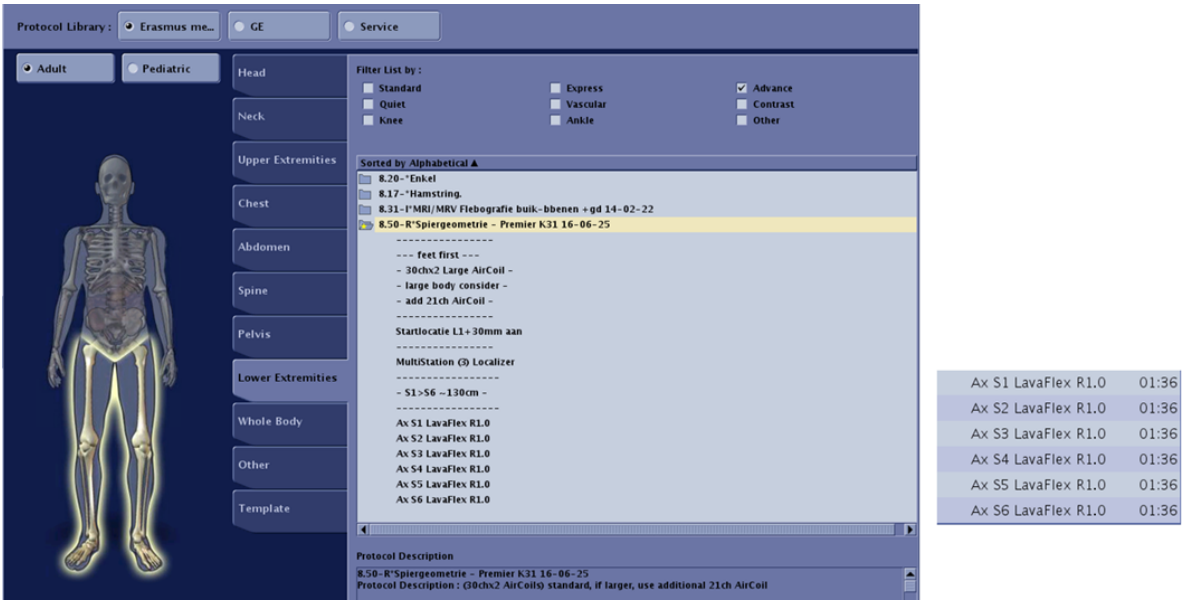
MRI protocol library selection screen (GE software). The highlighted protocol includes scanning from feet first using a 30chx2 Large AirCoil, starting location at L1+30 mm, and MultiStation Localizer imaging S1–S6 with LavaFlex R1.0 sequences.
